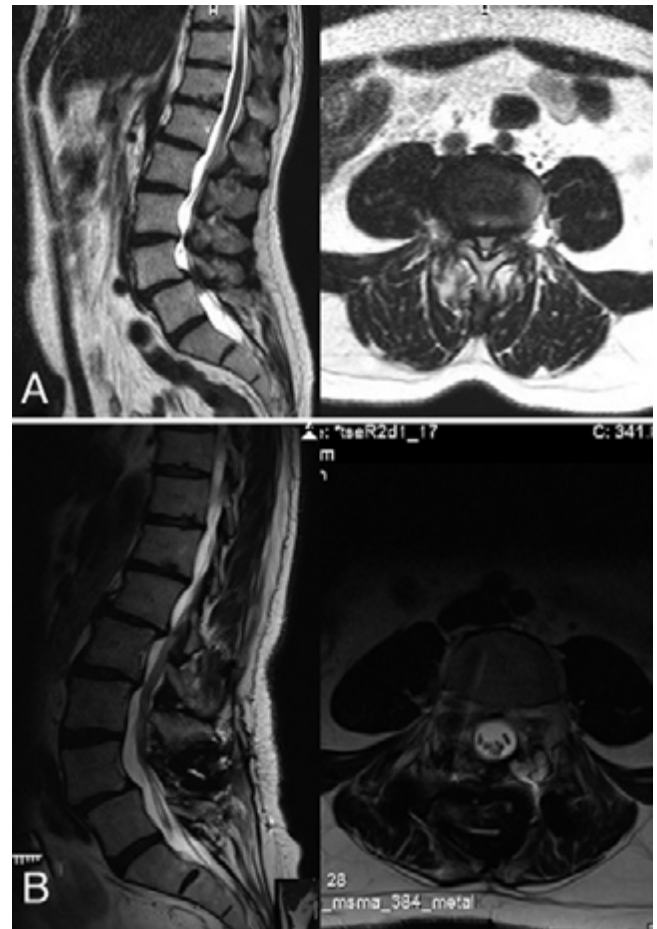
Sagittal and axial T2-weighted MR images obtained before surgery (A) and at the 11-year follow-up (B).
